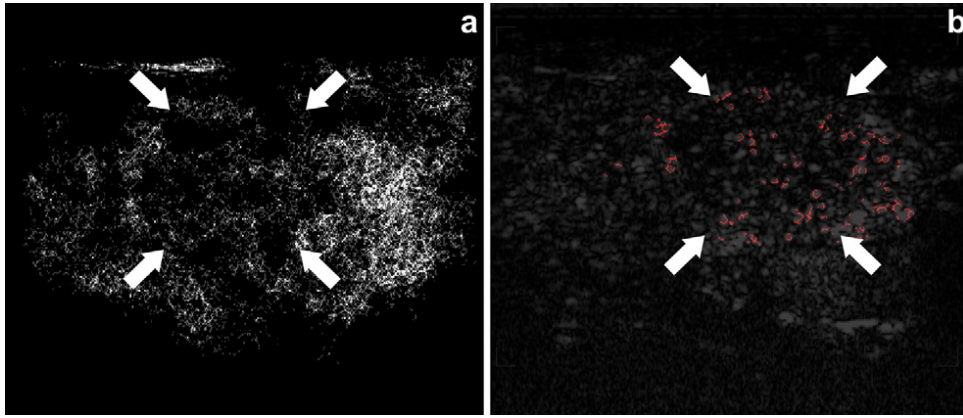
(a) Maximum intensity projection of the 3-D skeleton. (b) Contrast-enhanced ultrasound imaging (CEUS) image of a goiter nodule with corresponding skeleton overlaid in red. The white arrows indicate the nodule position. The lesion shows lower vascularity than healthy thyroid tissue.
